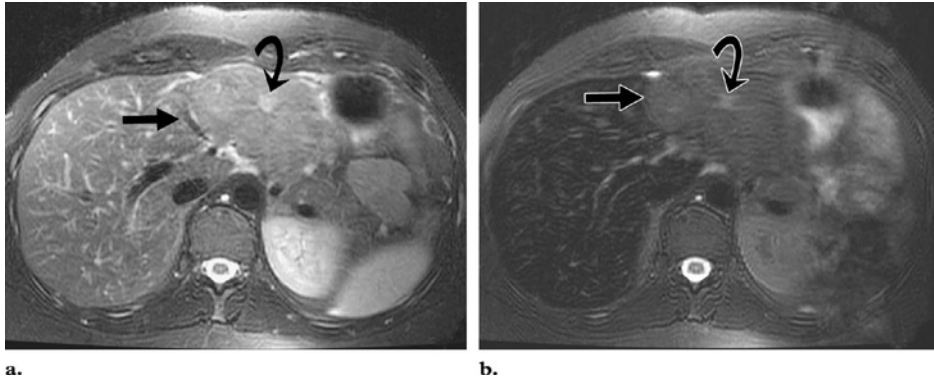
Appearance of typical FNH at superparamagnetic iron oxide (ferucarbotran)–enhanced MR imaging. a. Axial unenhanced T2-weighted fast SE image shows a large FNH lesion (straight arrow) that is isointense relative to the surrounding liver parenchyma. The central scar (curved arrow) has slightly higher signal intensity than the lesion. b. Axial contrast-enhanced fast SE image shows that the lesion (straight arrow) as well as the liver and spleen have decreased signal intensity due to the uptake of ferucarbotran into Kupffer cells. The central scar (curved arrow) does not contain Kupffer cells and has relatively increased signal intensity.
